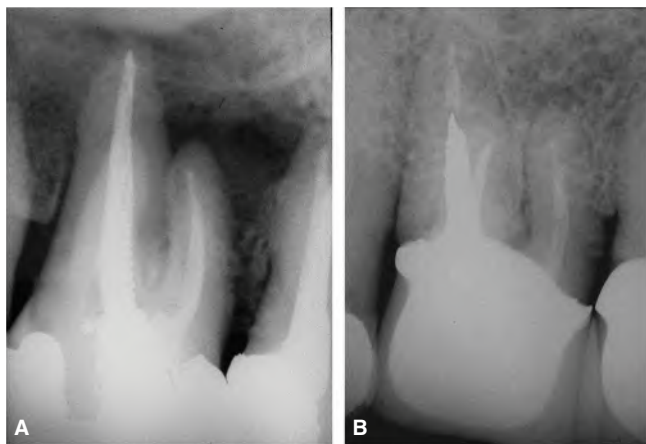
Long-term follow-up of nonsurgical endodontic treatment in a maxillary first molar of a 28-year-old male. A. Immediate postoperative radiograph showing a periapical radiolucency associated with the mesiobuccal root. B. 35-year follow-up radiograph showing marked reduction in size of the radiolucency. This may indicate a possible formation of apical scar.
